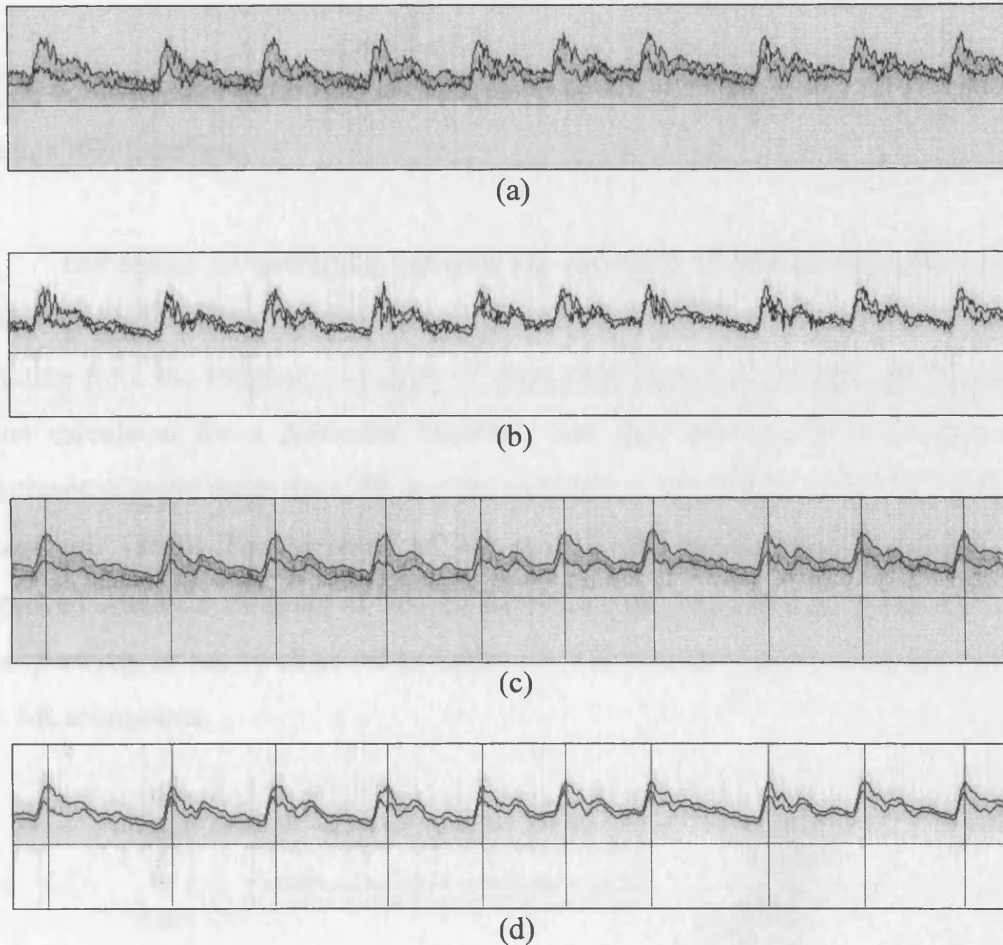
Raw maximum and mean frequency envelopes extracted from the (a) FFT (b) AR sonograms using the -6 dB threshold. Figures (c) & (d) show the low-pass filtered envelopes of (a) & (b) respectively and the comparison between the location of the systolic peaks for each heartbeat based on the FFT and AR sonograms.
